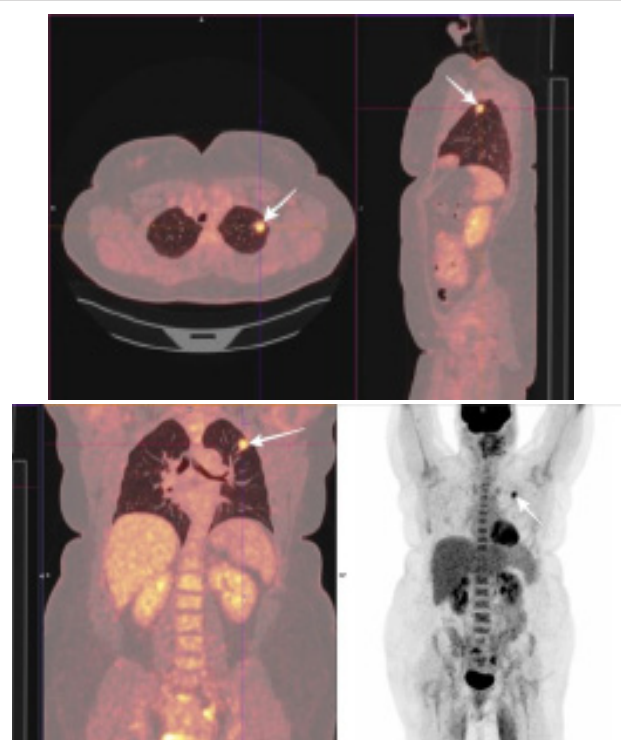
PET/CT images in different planes showing a suspected lesion in the left upper lobe (arrows) with increased radiotracer uptake.
